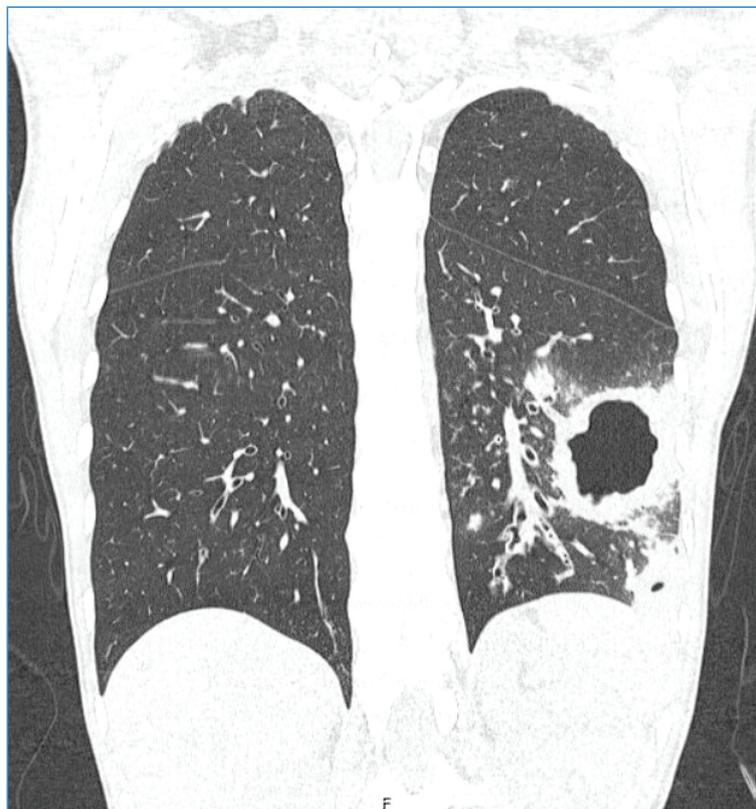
CT scan showing 3 new cavitated nodules 1 month after completion of antibiogram-guided antibiotherapy. The larger lesion was biopsied, with pathological fundings compatible with granulomatosis with polyangiitis.
